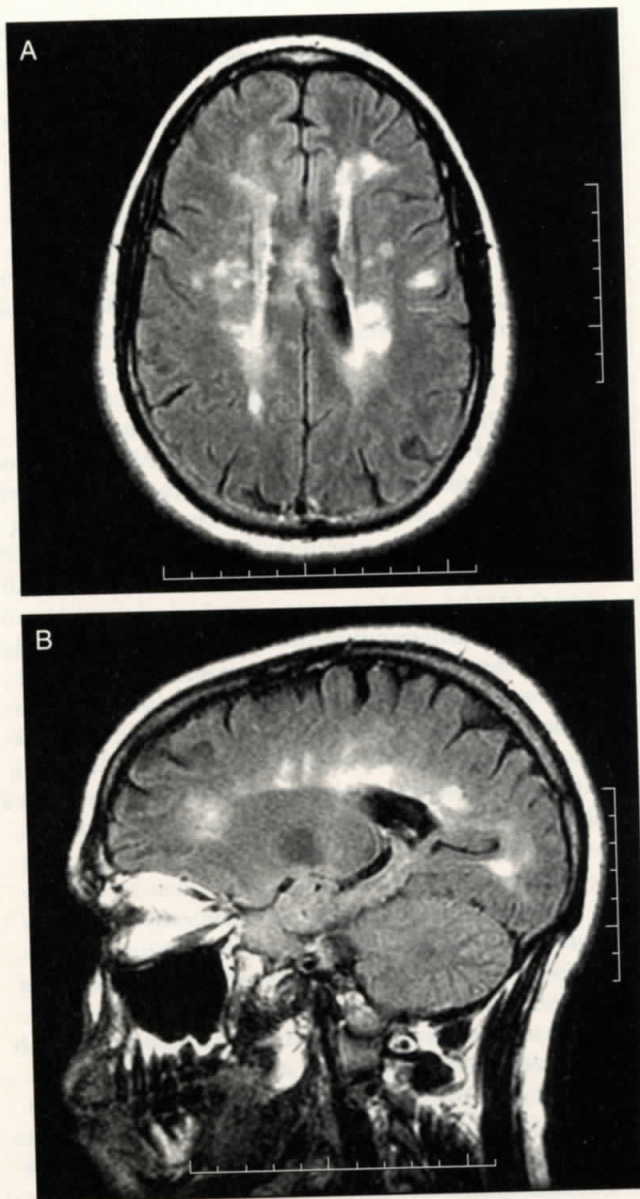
Fluid-attenuated inversion recovery (FLAIR) MR image showing abnormal areas. Hyperintense signal in periventricular white matter demonstrates characteristic pattern of a perivascular distribution (long axis perpendicular to body of lateral ventricle). A. Axial FLAIR image. B. Sagittal FLAIR image. (Image courtesy of University of Massachusetts Memorial Medical Center, Central Massachusetts Magnetic Imaging Center, Worcester, Mass.)
